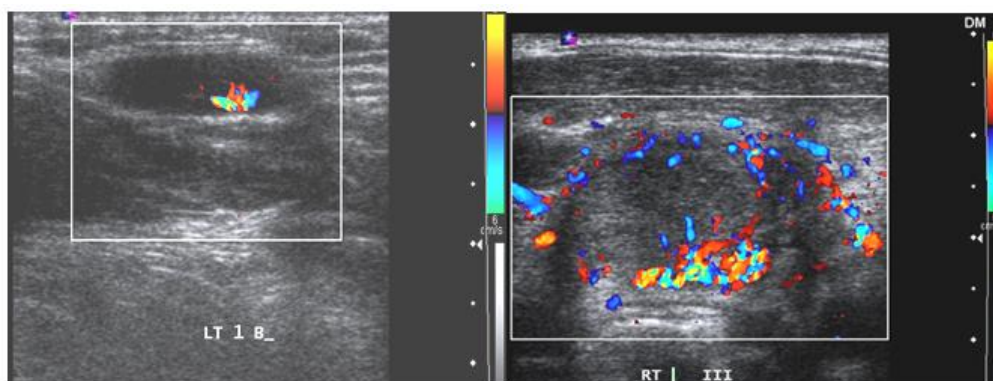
A, B, C & D. Different patterns of vascularity on color doppler.
